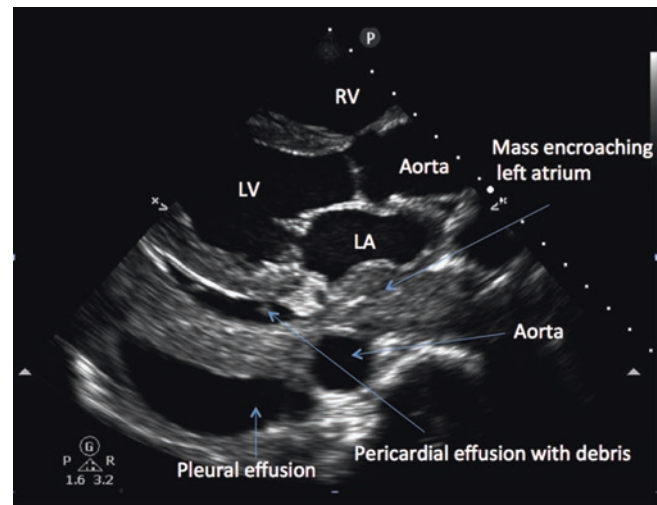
Cardiac ultrasound in a patient with advanced cancer. A point-of-care ultrasound shows pericardial effusion with debris, pleural thickening, and left-sided pleural effusion in an elderly male with dyspnea. Pericardial effusion is seen in this parasternal long axis view as an echo-free space posterior to the heart but anterior to the descending aorta. Pleural effusion is seen as an echo-free space posterior to the aorta. A mass encroaching onto the left atrium is also seen. This patient was diagnosed with advanced widespread lung cancer. See also Video 37.11
